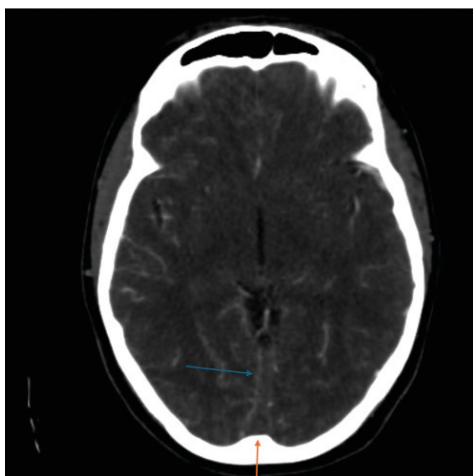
Computed tomography angiography of the skull showing: failure of the straight sinuses to fill (blue arrow) and confluence of the sinuses or torcula (orange arrow).
